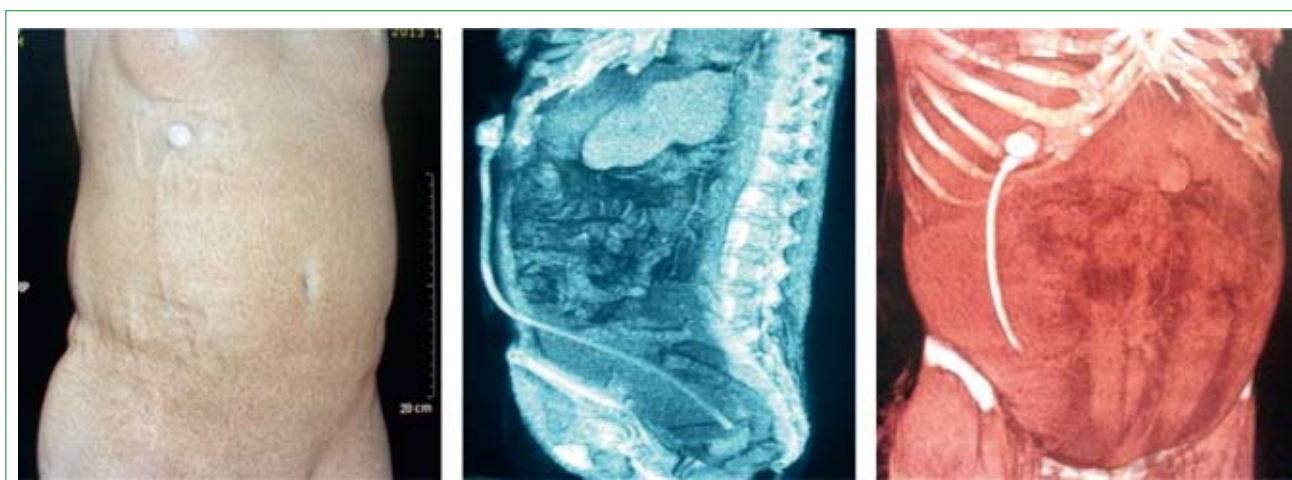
Computed tomography of the PPS implanted in the abdominal cavity of the three-dimensional reconstruction
